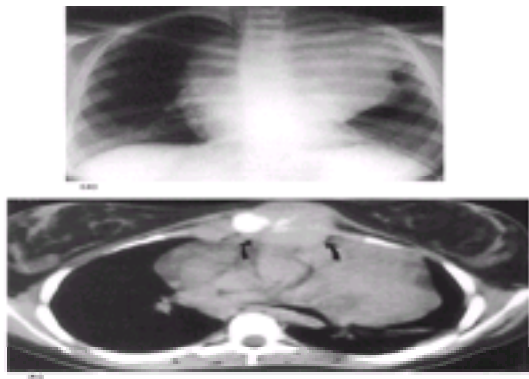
(a) Chest radiograph obtained in a 12-year-old girl because of mild left pleuritic chest pain shows a large anterior mediastinal mass. (b) The CT scan revealed that the mass was eroding through the chest wall and sternum (arrows). Because of significant tracheal compression, a biopsy was obtained under local anesthesia, and Hodgkin's disease was diagnosed.
